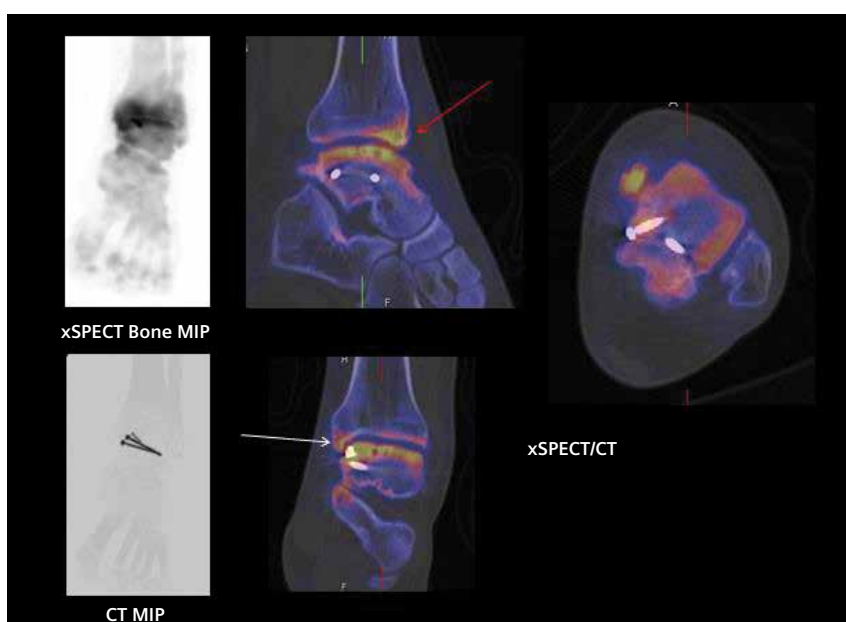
Fused images of CT and xSPECT Bone show increased uptake in the anterior lip of the tibial condyle, which reflects anterior impingement between the anterior edge of the tibial articular surface and the talar articular surface (red arrow). The talar articular surface appears irregular with multiple subchondral cysts and skeletal hypermetabolism throughout the articular surface, reflecting osteoarthritic changes. The medial malleolus of the tibia also shows focal increase in uptake (white arrow), probably secondary to reactive changes due to impingement in the medial aspect of the talo-tibial joint, due to the extruded end of the second talar screw that is visualized in the coronal images.
